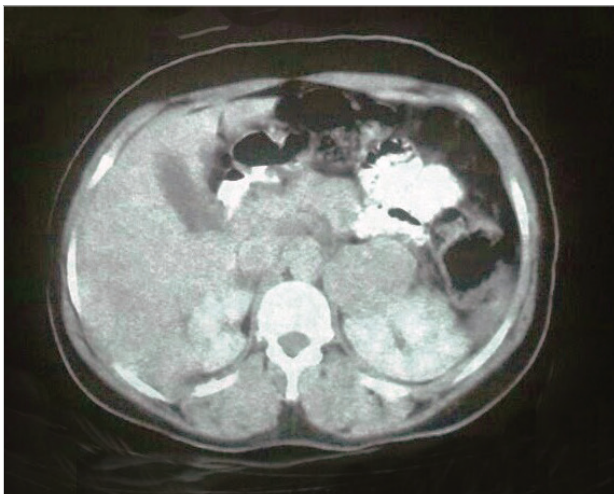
Case 12, metastatic adrenal carcinoma, computed tomography view
